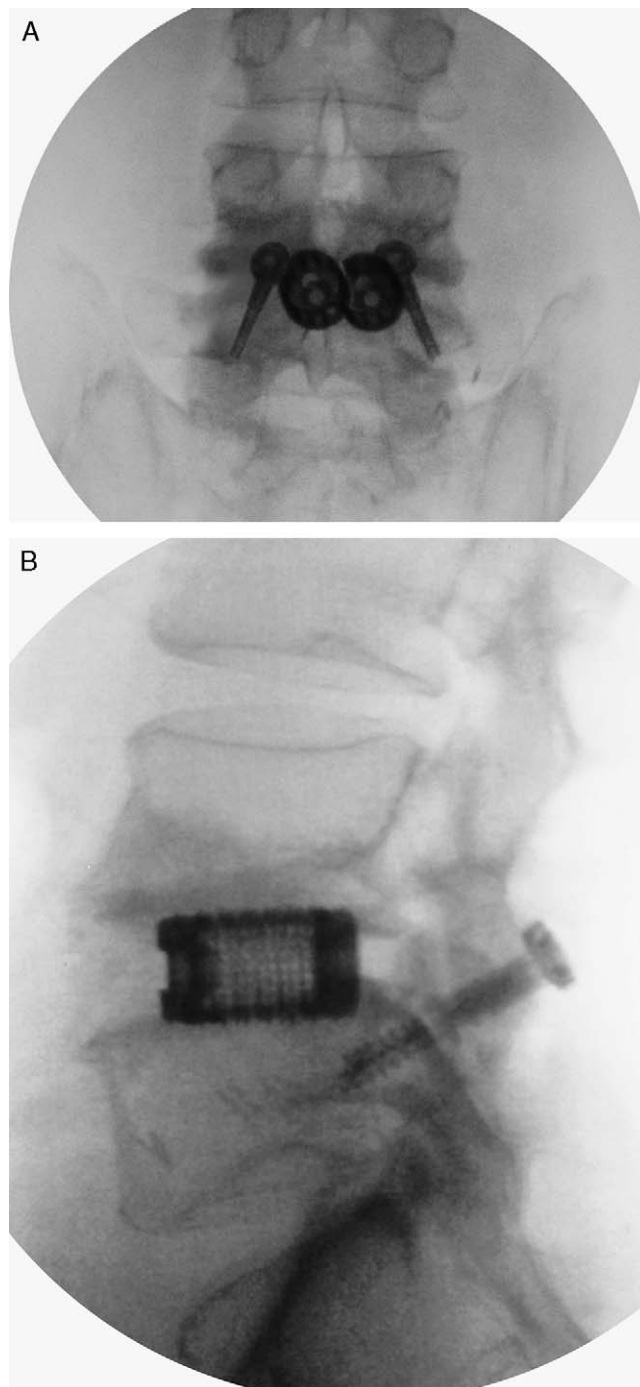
A/B, Radiograph of anteroposterior and lateral views of transfacet fixation.
